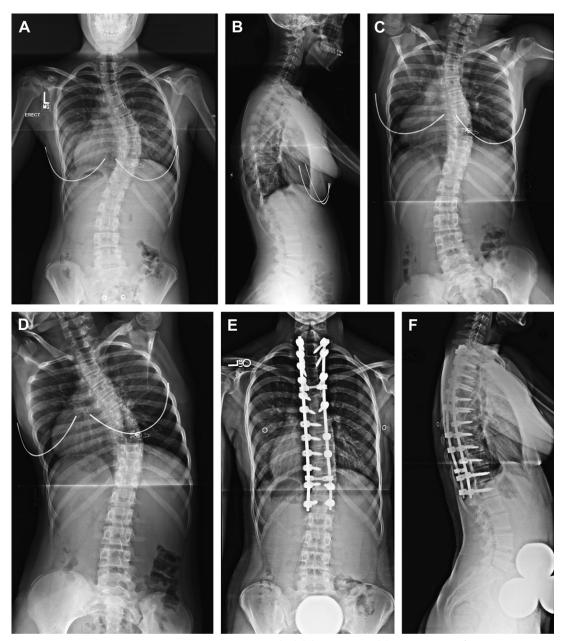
Lenke 1. Preoperative standing posteroanterior (PA) (A) and lateral (B) radiographs of an 11-year-old girl with a right 50° main thoracic curve and a 25° left lumbar curve. Right (C) and left (D) bend films show that the main thoracic curve bends down to 28° and the lumbar curve bends down to 4°. Two-year follow-up PA (E) and lateral (F) radiographs show correction of the main thoracic curve to 15° and correction of the lumbar curve to 3° with posterior pedicle screws from T2 to L1.
